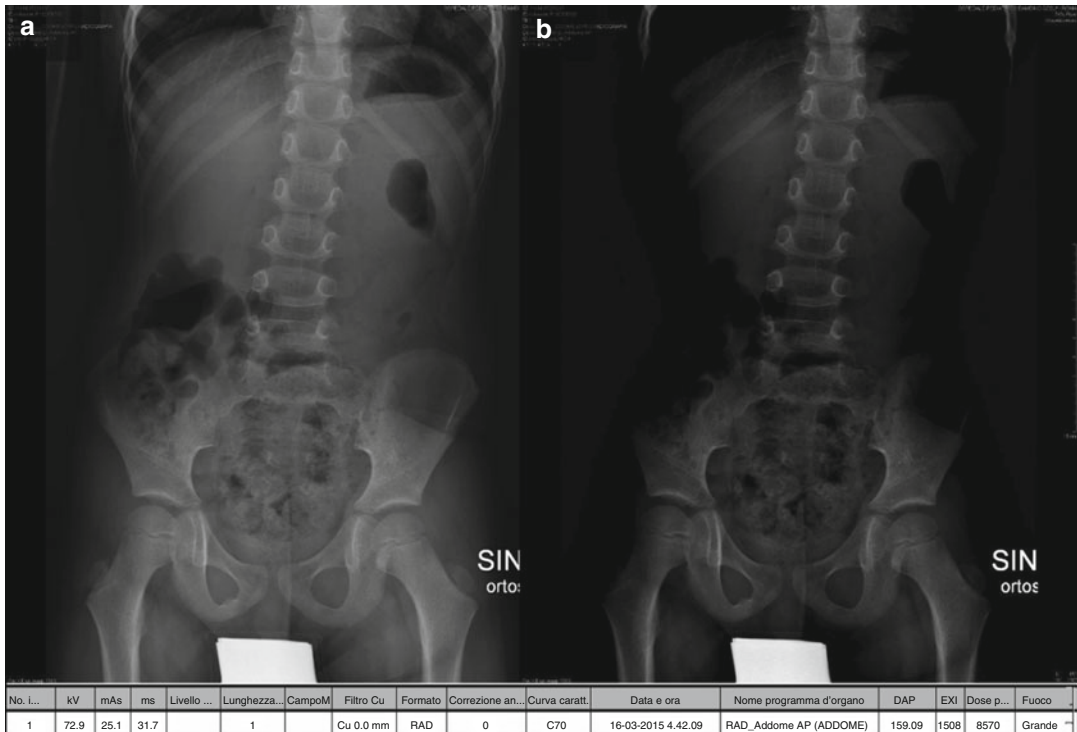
An example of DR overexposure in abdominal x-ray of a 5-year-old male child. Note in (a) how the post-processing can compensate the original overexposed
